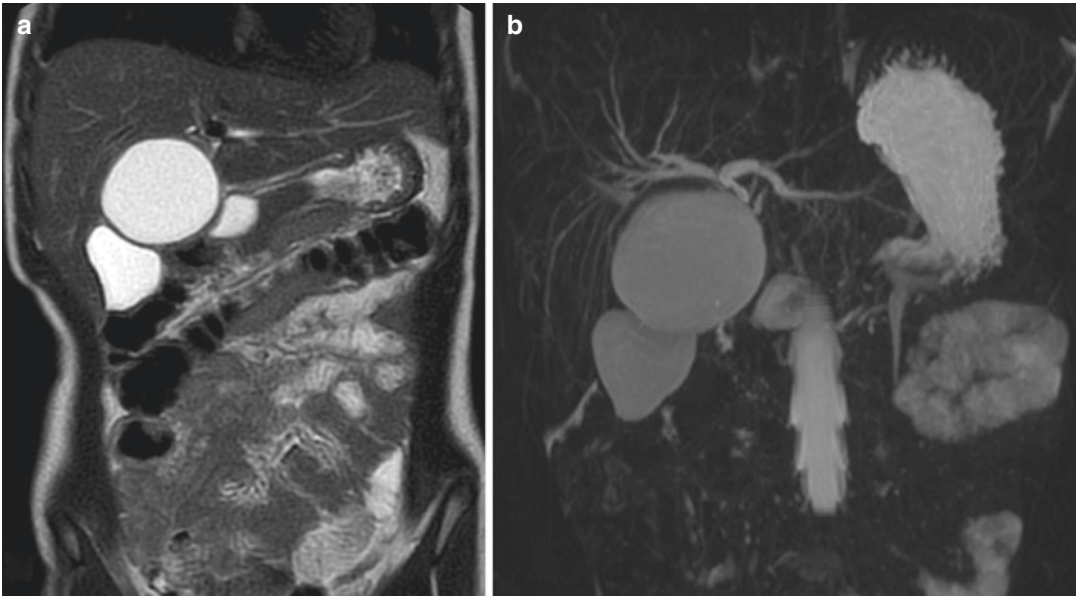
Coronal MRI: T2-weighted image shows a large fluid mesenteric cyst in the right abdomen
